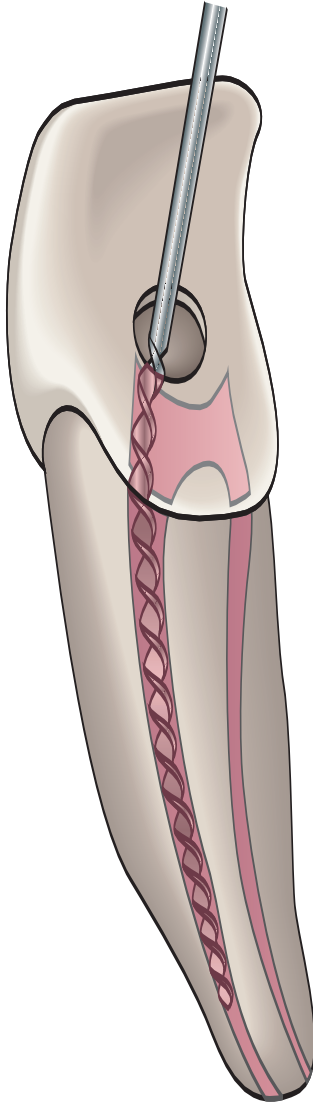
Operative errors—mandibular anterior teeth. Again, inadequate access prevents the exploration for a second canal toward the labial. Straight-on radiographs do not reveal this common error.
